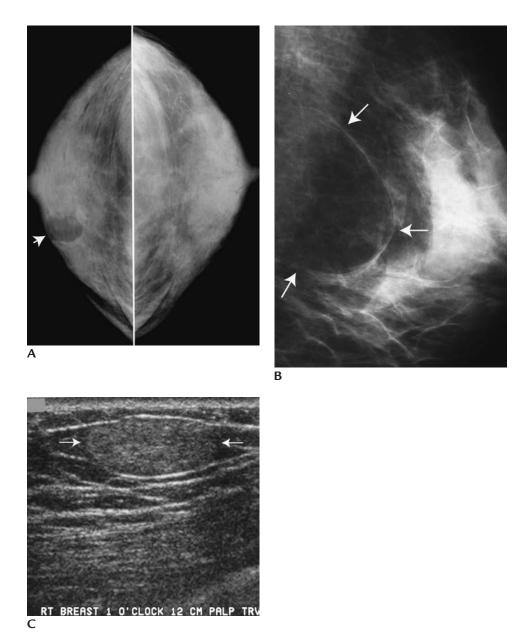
Lipomas. (A) Oval mass (*arrow*), fat containing, with circumscribed margins. (B) Different patient. Oval mass, fat containing, delineated by thin pseudocapsule (*arrows*). Lucent masses in the breast are benign. (C) Different patient. Homogeneously hyperechoic oval mass (*arrows*) with circumscribed margins. Unlike oil cysts that are often anechoic or complex cystic in appearance, lipomas are solid on ultrasound.
